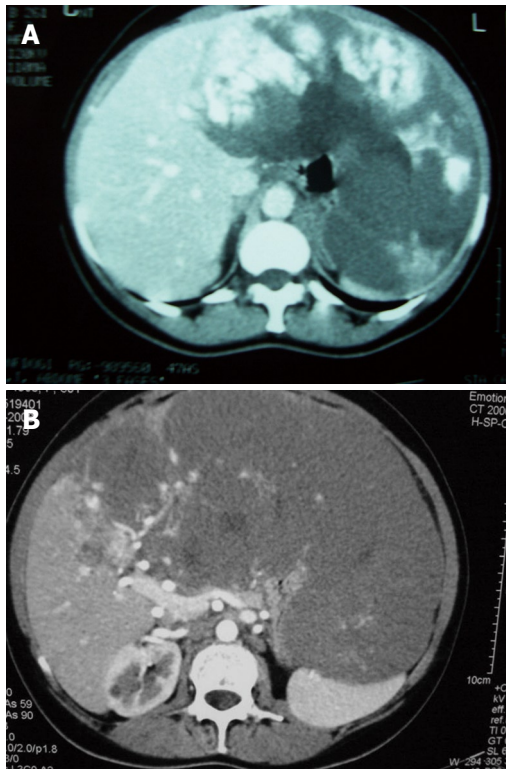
Computed tomography scan of a patients with a liver hemangioma. A: The first scan performed 7 years ago, showing an oversized hemangioma on the left hepatic lobe; B: During the symptoms worsening a second CT-Scan showed tumor growth. The lesion reached the central portions of the liver.
